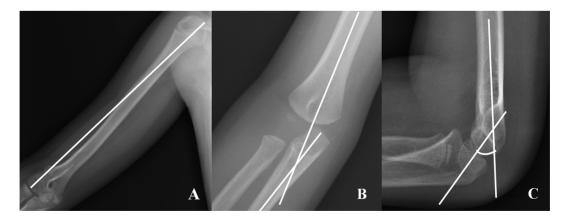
Radiographic measurement of humeral length (a), humeral-ulnar angle (b) and shaft-condylar angle (c).
